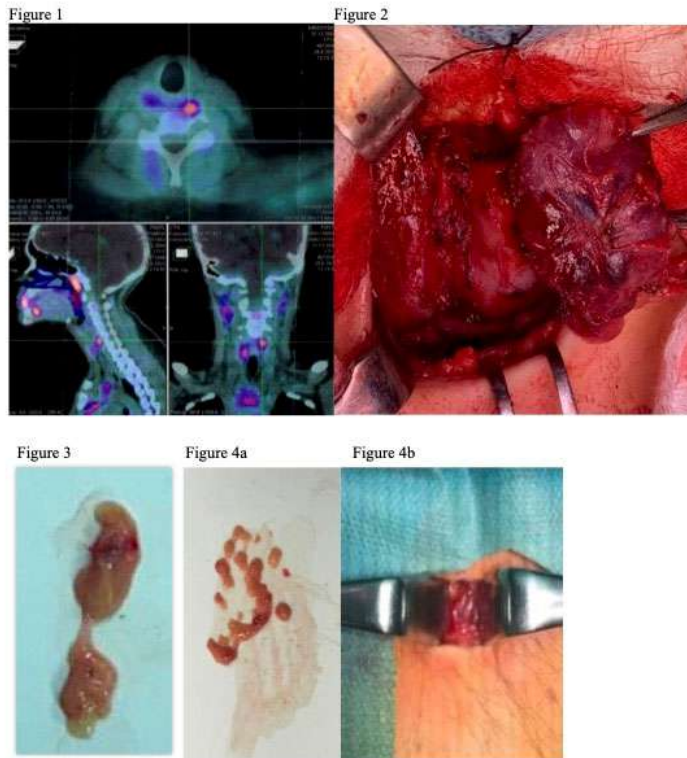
PET-CT F18 Cholin revealed hyperplasia of the left parathyroid
